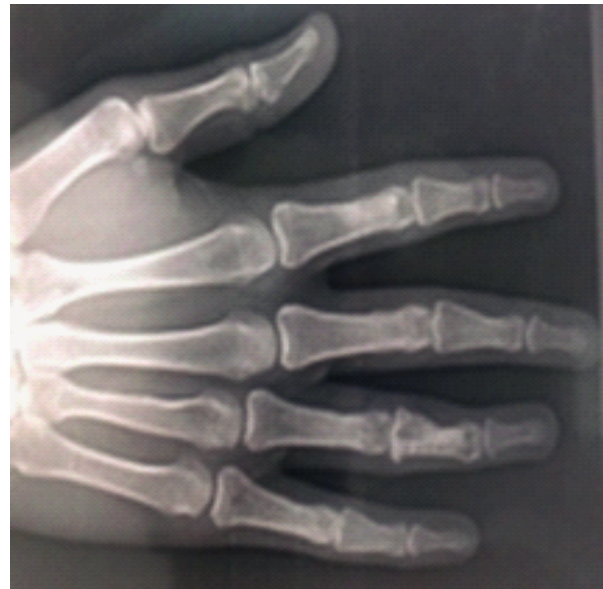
Post-operative radiograph after 2 years
